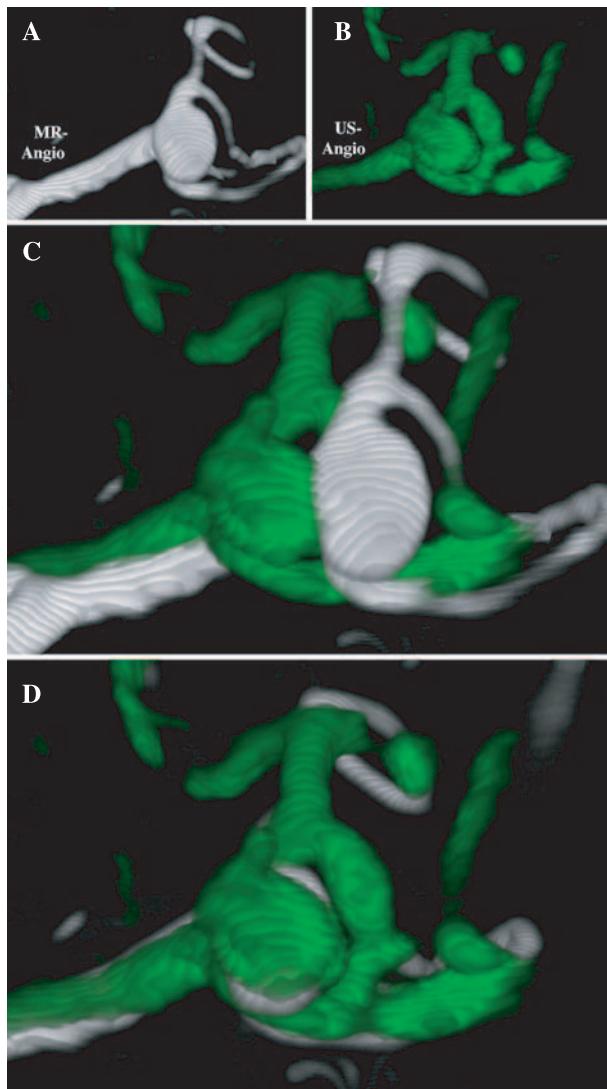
Automatic multimodal volume-to-volume registration between (A) MR angiography data (MRA, gray) and (B) Power Doppler based ultrasound angiography data (USA, green) of a middle cerebral artery aneurysm. (C) Before registration: the mismatch between the MRA volume and USA volume is the same as the shift experienced during surgery in the navigation system. (D) After automatic MRA to USA registration the match is satisfactory, but as we can see the two volumes are not completely identical as the two modalities image different physical properties
